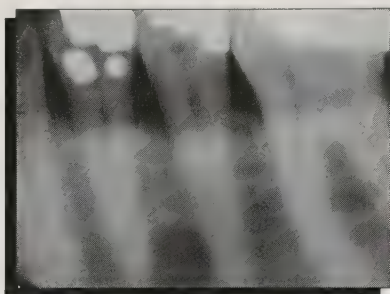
Periapical radiograph of an LPC at the time of discovery. Note the characteristic location, shape, internal structure and effect on teeth.
